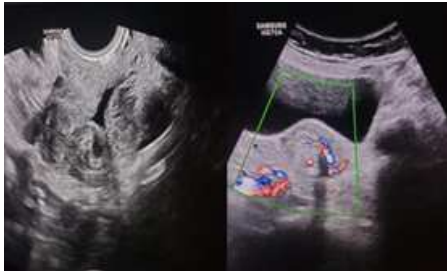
Non-contrast ultrasonographic longitudinal (3a) and transverse doppler (3b) pelvis images show bulky left adnexa with indistinct contour showing swirling of left adnexal vessels.
